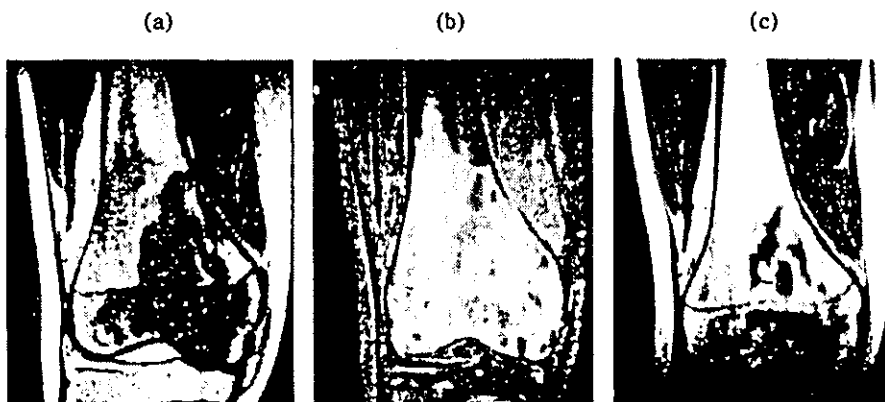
MRI findings in the right knee joint at the time of diagnosis. MRI of knee joint showed irregular shaped low signal intensity in the subchondral region on T1-weighted images (a) and peripheral rim enhancement on Gd-DTPA enhanced fat suppression images (b). T1-weighted MR images sixteen months after onset of bone marrow necrosis. Low signal intensity areas in knee joint have been reduced (c).
